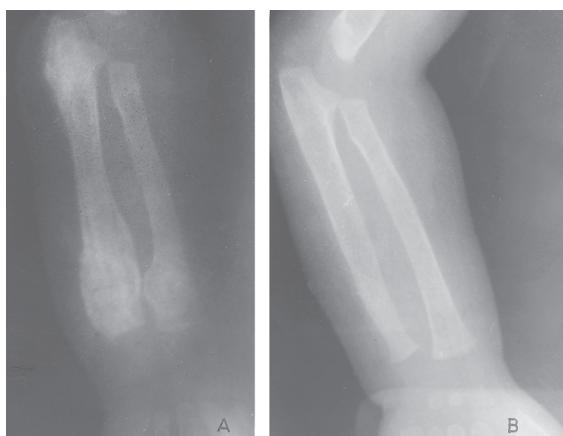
a) Initial X-ray of right forearm shows osteolytic lesions consistent with osteomyelitis. b) Normal X-ray findings after treatment.
